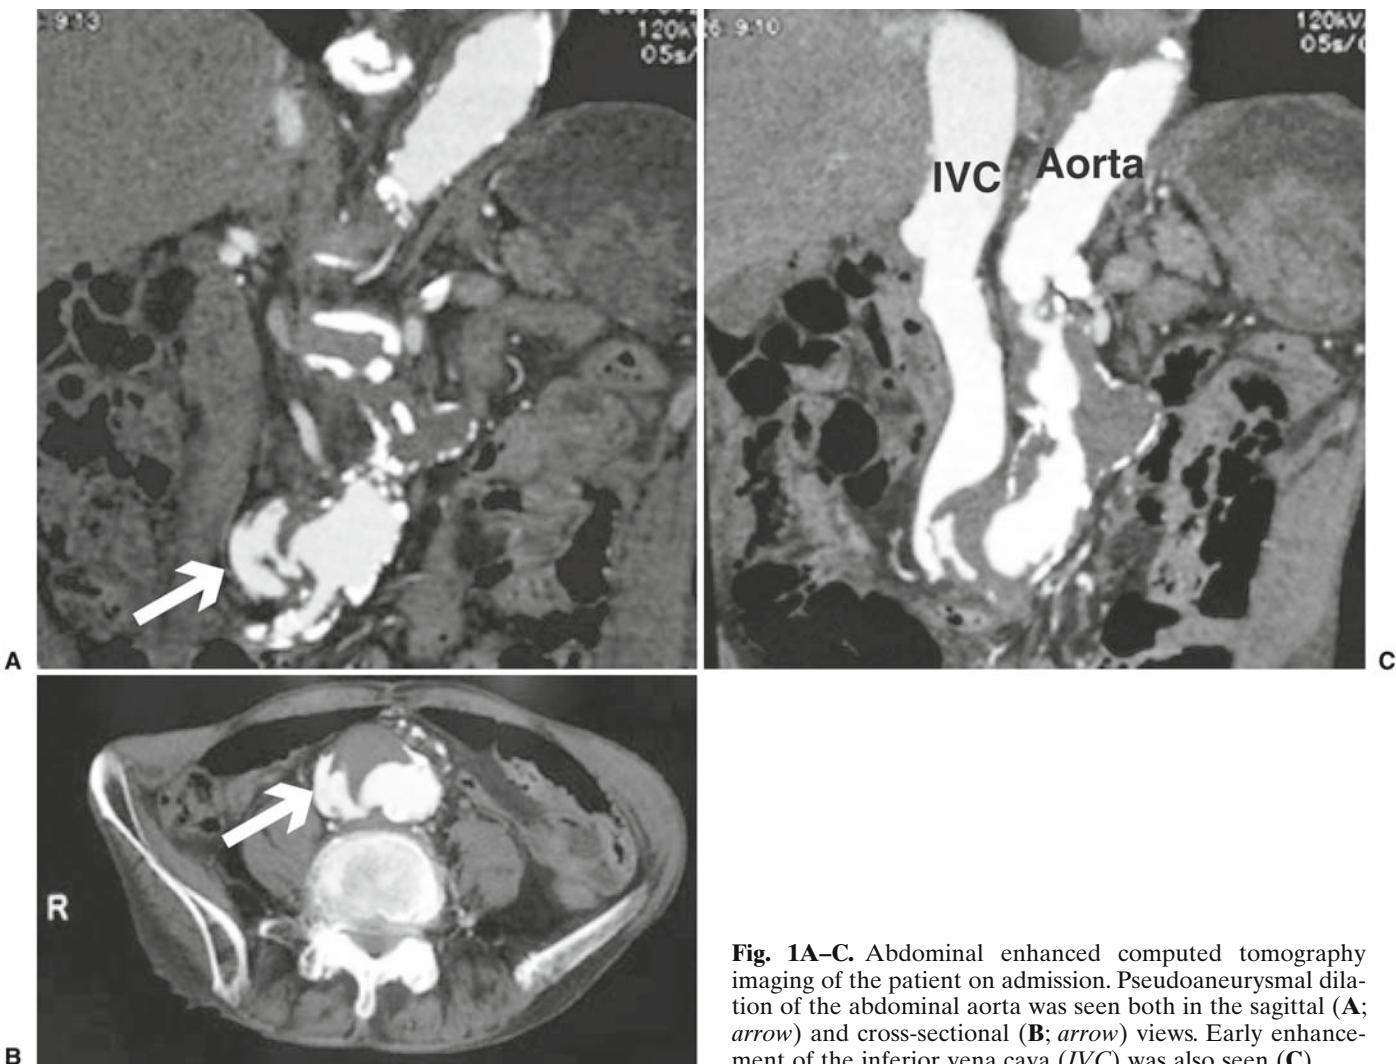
Abdominal enhanced computed tomography imaging of the patient on admission. Pseudoaneurysmal dilation of the abdominal aorta was seen both in the sagittal (A; arrow) and cross-sectional (B; arrow) views. Early enhancement of the inferior vena cava (IVC) was also seen (C)
